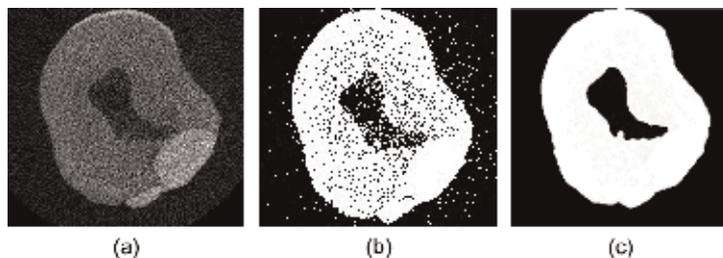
A 2D slice of a CBCT image affected by salt-and-pepper (impulse) noise. (a) Original image; (b) improper root canal recognition in the original image as a result of thresholding without filtering the noise; and (c) segmentation after median filtering.
